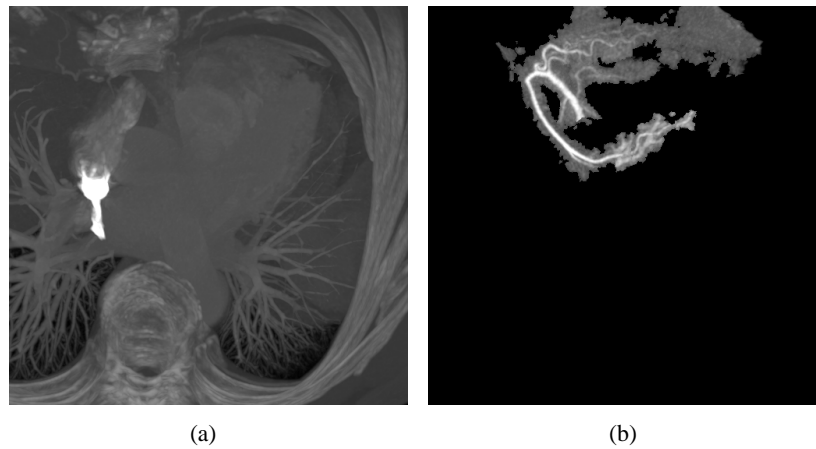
A coronary CTA dataset. (a) MIP of the original volume, where the coronary arteries are completely masked by other, brighter components in the image. (b) MIP of the segmented right coronary artery.
